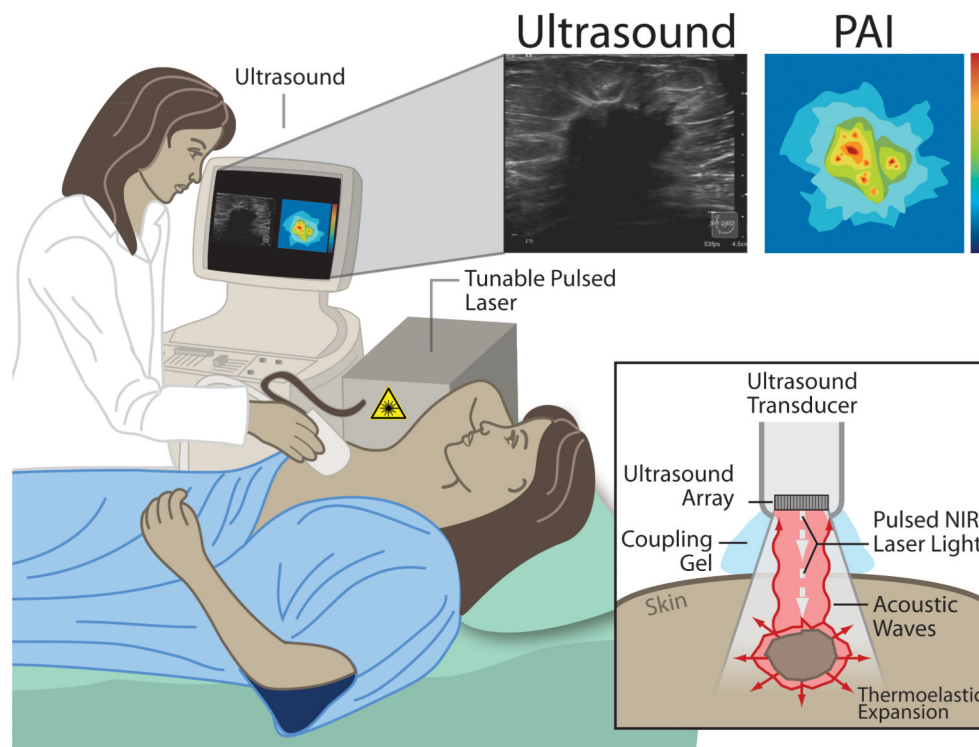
Principles of photoacoustic imaging (PAI) presented for a potential clinical application: diagnostic breast imaging by integrated real-time photoacoustic/ultrasound imaging. The laser sends nano-second pulses of near-infrared light through the transducer into the tissue. This light is then absorbed inside the tissue (at different levels for each tissue type/component) causing a localized transient thermoelastic expansion. This expansion leads to the emission of pressure waves (ultrasound), which can be detected by the array in the transducer. Finally, a photoacoustic image is calculated and displayed in real-time. At the same time, the ultrasound system can be used in its b-mode to provide structural information about the tissue, in addition to the functional/molecular information obtained by PAI, and both images can be displayed on the view
